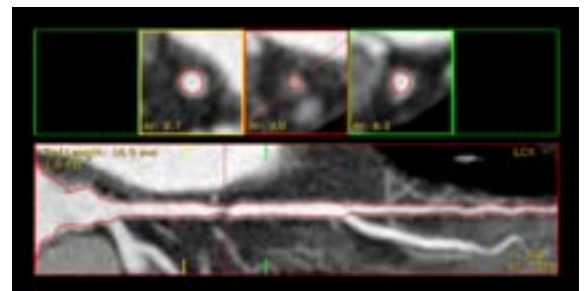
Clinical History: This asymptomatic 59-year-old male had a strong family history of coronary artery disease (CAD). A cardiac CT examination was performed for further evaluation. There is a lesion with non-calcified plaque (60% area stenosis) present in the proximal left circumflex artery. Parameters: Brilliance CT 64-channel scanner; 14 sec scan time, 140mm scan length, 0.9mm slice thickness, 0.5mm slice increment. Essence technology: AMR, Segmented Anode, Nano-Panel detectors.
